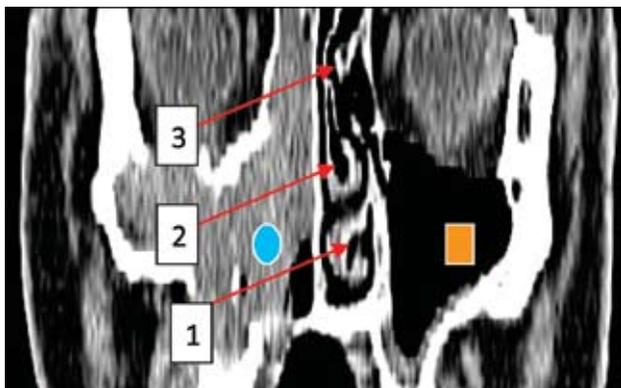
Cranio-facial CT scan, bone window, axial slice (a) and coronal reconstruction (b, c): a) bilateral inferior turbinate pneumatization (red arrow): on this slice, at this level can't be identified the communication with the maxillary sinus; maxillary sinus (♦); rhinopharynx (⊗); b) on the coronal reconstruction (red arrow) the communication with the left maxillary sinus can be seen; the pneumatization of the right inferior turbinate remains isolated by the sinus. c) 1. Right concha bullosa; 2. Left nasal septum deviation, on the other side of the middle turbinate pneumatization; 3. hypertrophy of the left middle turbinate
